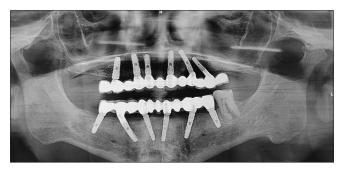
Orthopantomogram with definitive prosthesis
